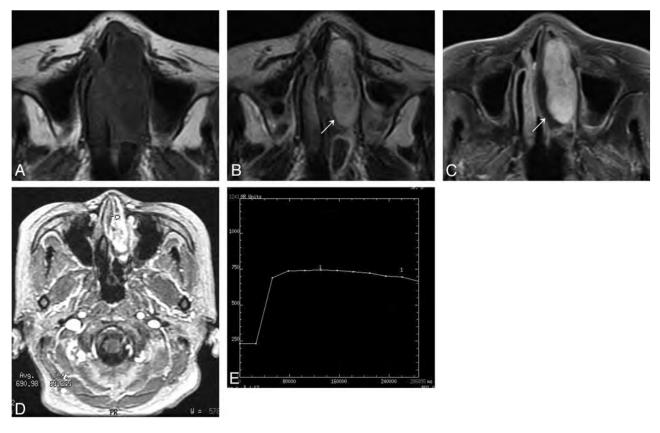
Woman, 74 years old. *A*, Axial TI-weighted MR imaging shows a homogeneous isointense signal mass in the left nasal cavity. *B*, Axial T2-weighted MR imaging shows a heterogeneous high signal mass with a thin peripheral isointense signal ring (\nearrow). *C*, Axial enhanced MR imaging shows marked tumor enhancement with a nonenhanced thin peripheral ring (\nearrow). *D*, The round cursor marks the region of interest of the lesion selected for signal intensity measurement at dynamic MR imaging. *E*, Corresponding axial DCE MR imaging depicts a plateau pattern (type II) TIC.
